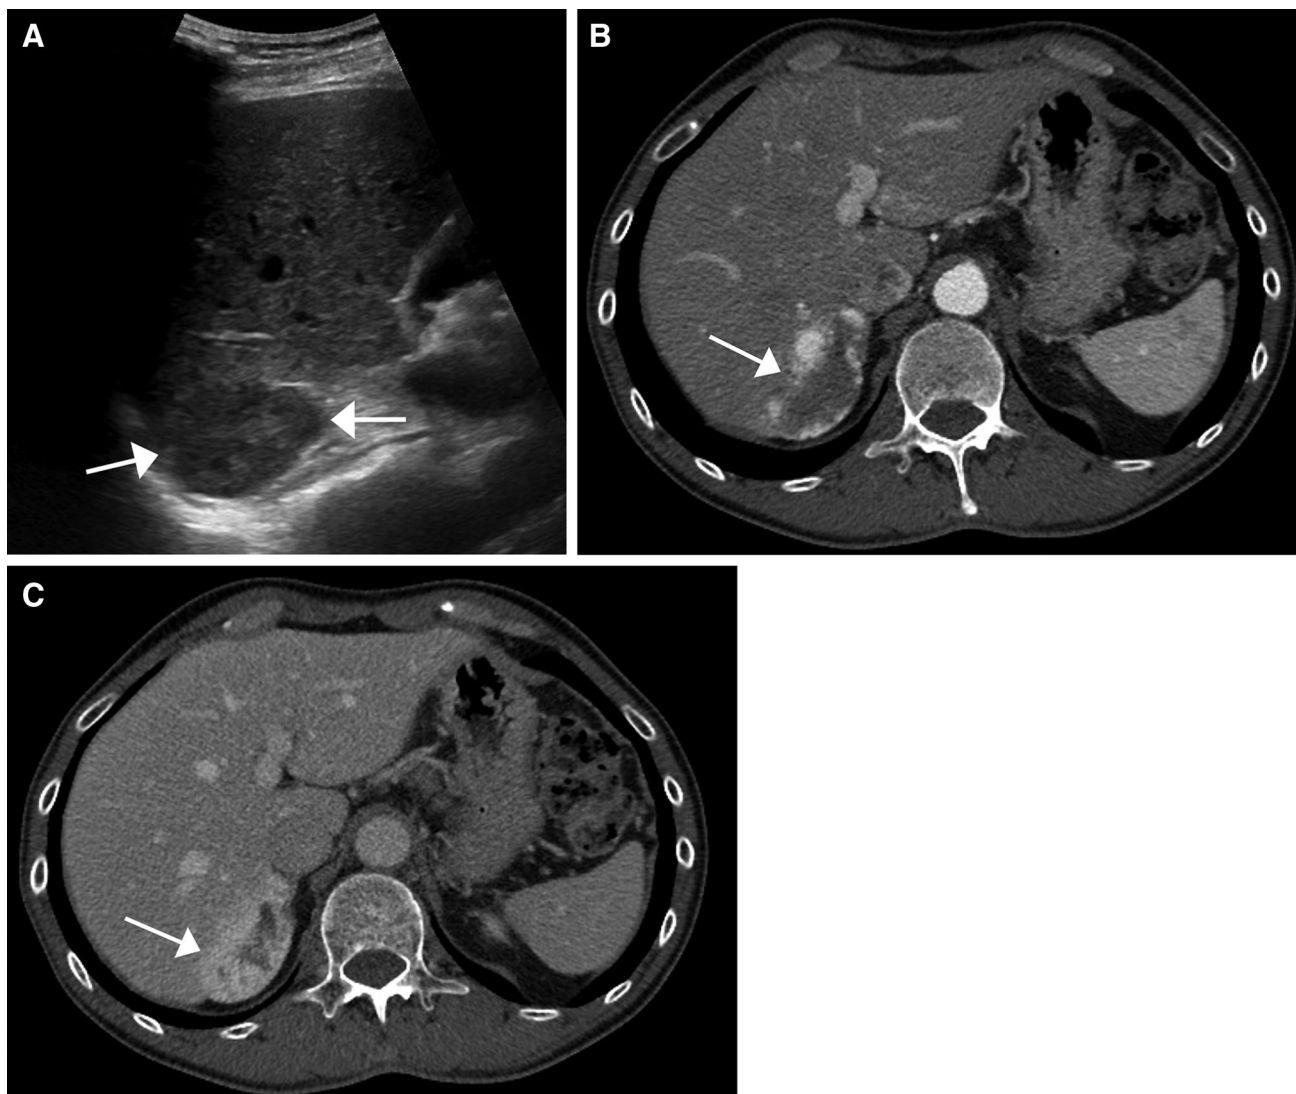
LI-RADS US-1: Negative on screening exam for a 49-year-old male with chronic hepatitis B. A Large irregular hypoechoic mass on ultrasound would be suspicious for possible HCC without prior imaging and would be US-3 (*arrows*). However, prior CT definitively characterized this
